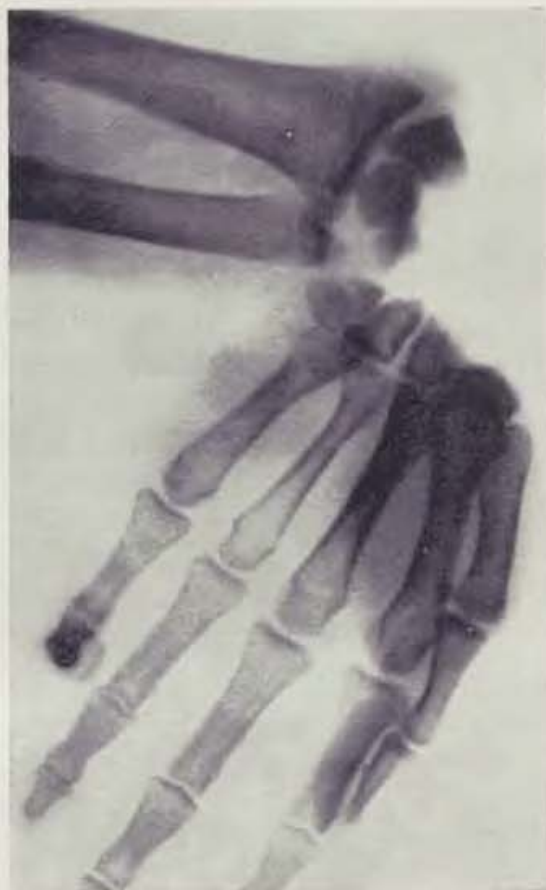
X-ray of the patient's hand on admission. Disarticulation between the two carpal rows can be seen
